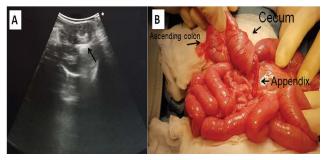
(A) Ultrasonography showed a target lesion (black arrow) over left upper quadrant of abdomen; (B) Operation finding: ileo-cecal type intussusception with non-fixation of ascending colon.
